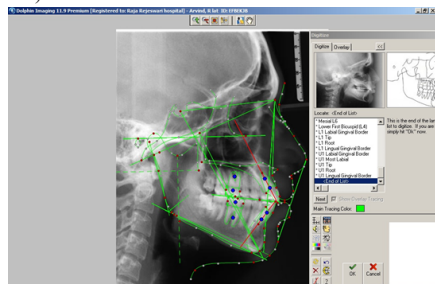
Digitization Of Radiographic Images In DOLPHIN Imaging(ver 11.9).
